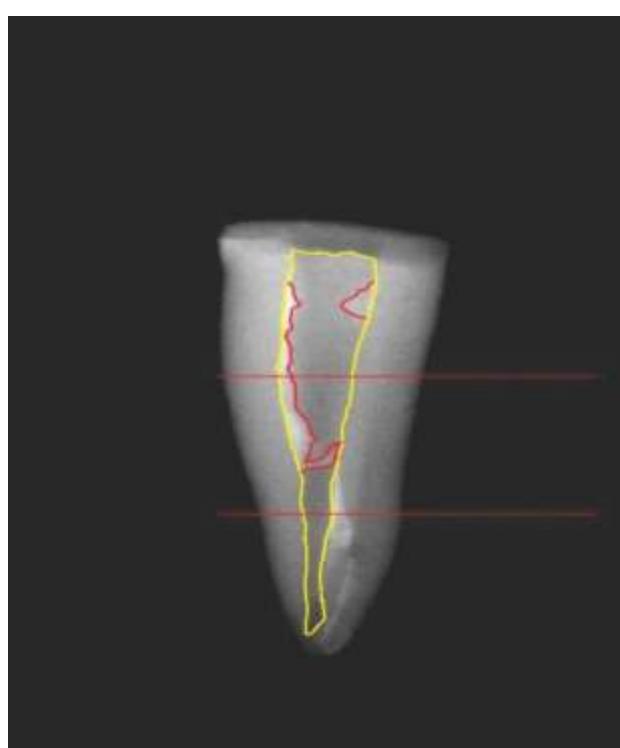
Radiograph of Sample Tooth Showing Residual
